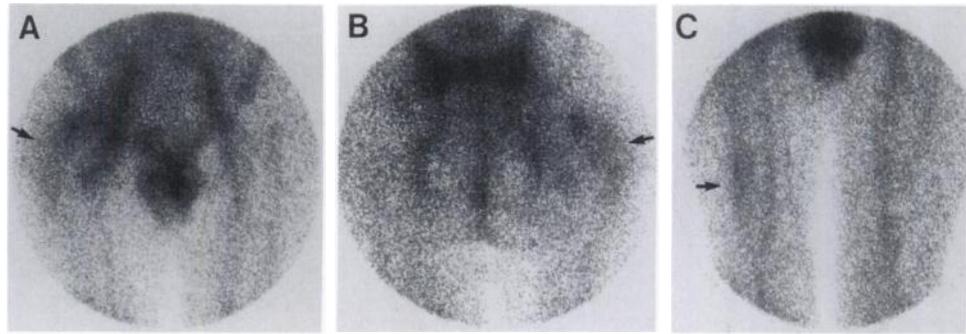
is a typical example of an  $^{111}\text{In}$ -IgG scintigram of an infected total hip arthroplasty with increased uptake in the right acetabular region with extension in the surrounding soft-tissue (Fig. 1A-B) and increased uptake around the tip of the femoral component of the prosthesis (Fig. 1C).
